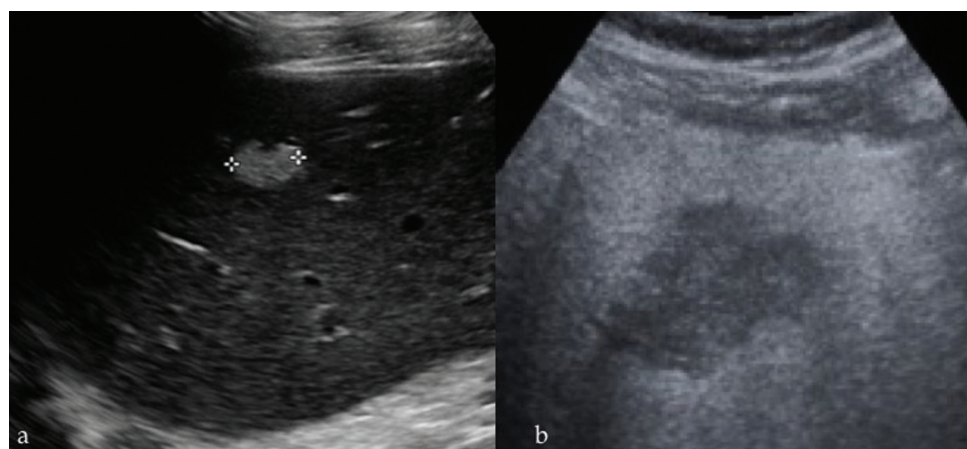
a. Ultrasound of a haemangioma in a normal liver. It is well-defined and echobright. This appearance is diagnostic of a haemangioma without further imaging. b. Ultrasound of a haemangioma in a fatty echogenic liver. It appears hypoechoic and needs further imaging to characterise.
